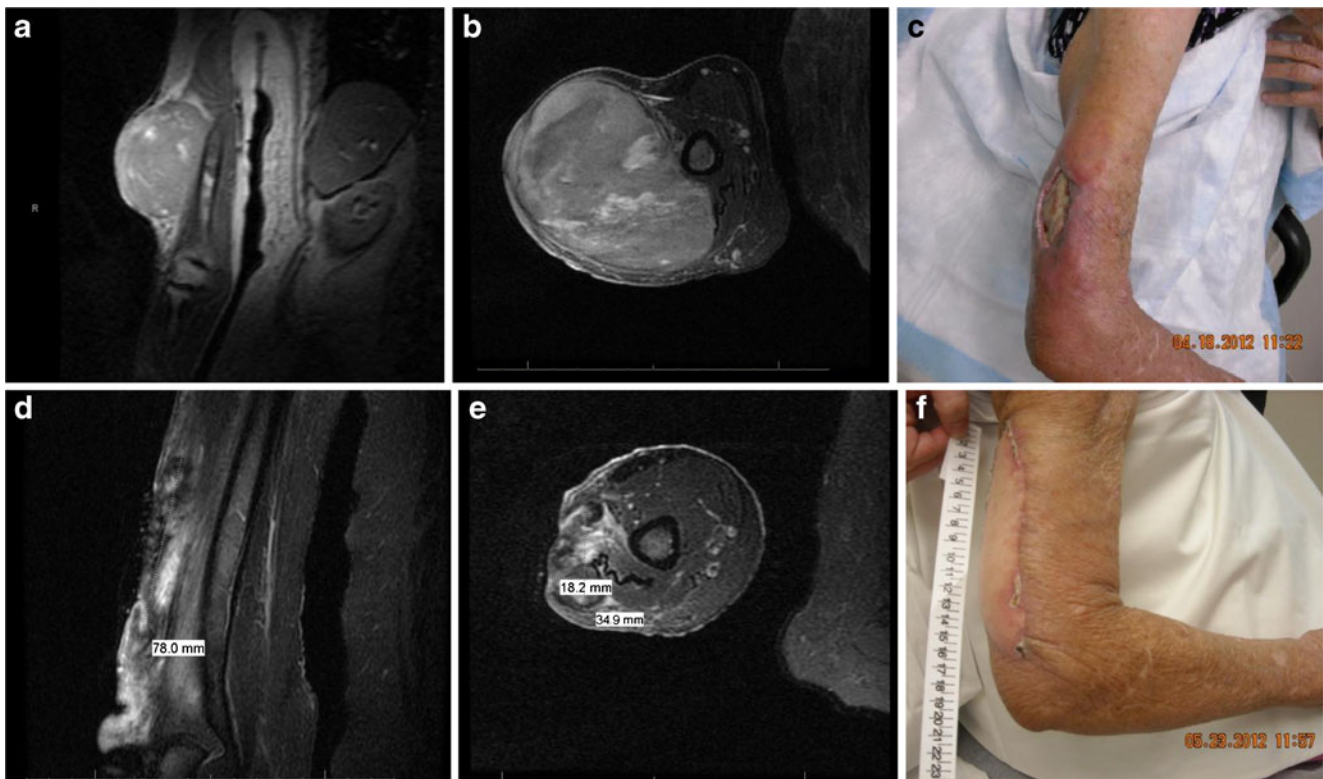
Clinical and radiographic tumor response to neoadjuvant radiation. a Coronal MRI of right upper arm prior to start of radiation treatment. b Axial MRI of right upper arm prior to start of radiation treatment. c Right upper arm before surgery and 6 weeks after completion of radiation. d Coronal MRI of right upper arm 6 weeks
